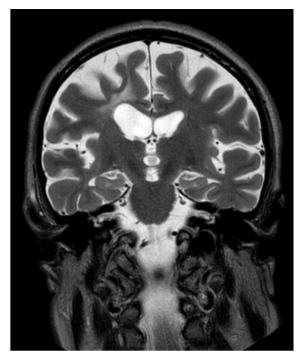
Treatment with rituximab 1000mg 6/6 months was started with resolution of the mesodiencephalic lesion (T2-weighted images).
